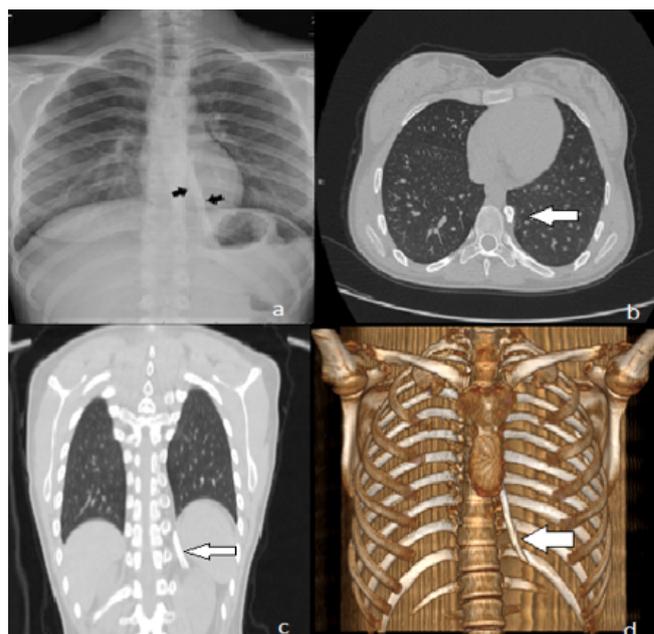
Posteroanterior chest graph shows an accessory rib (arrows) located on the left lateral side of corpus of T6 vertebrae (a), lung window CT image shows an abnormal thoracic rib (arrow) (b), coronal window CT image shows an abnormal thoracic rib (arrow) (c), three-dimensional CT reconstruction image of the bone shows an abnormal supernumerary intrathoracic rib (arrow) (d).
